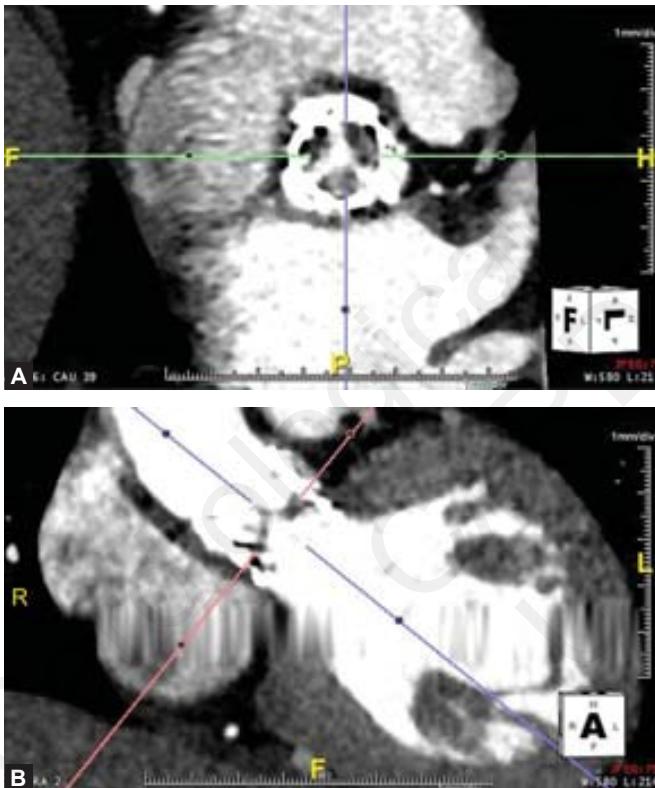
Post-transcatheter aortic valve replacement CT imaging with contrast showing hypoattenuated leaflet thickening.
